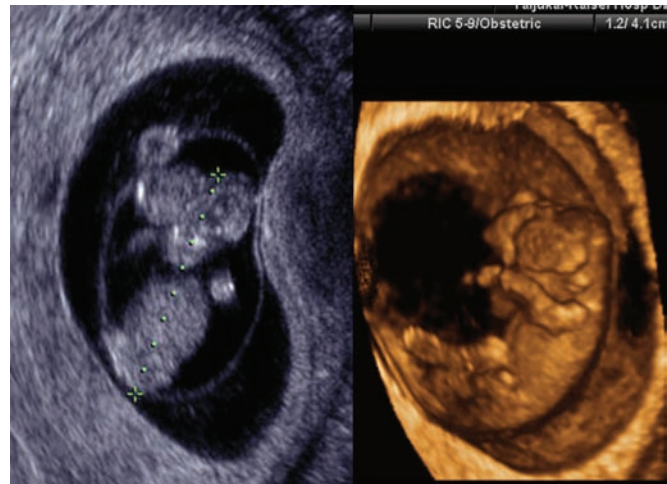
Acrania at 10 weeks of gestation. (Left) Ultrasound coronal image at 10 weeks. Note the normal appearance of amniotic membrane, which indicates that this condition is not amniotic band syndrome. (Right) Three-dimensional ultrasound image of the same fetus as in the left image.
